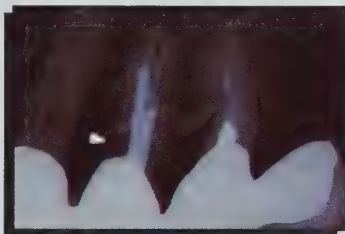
Periapical radiograph made of the repaired washout defect on tooth 24 after six years in function. The area still has the characteristic washed-out look (arrow) due to the removal of carious tooth structure, but no further breakdown was noted clinically.
